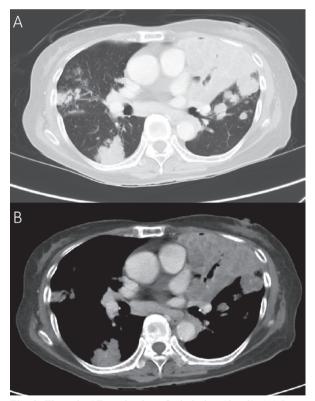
Thoracic CT on the day of admission (day 0). (A) Lung window of thoracic CT showed multifocal, conglomerated soft tissue at the bilateral lungs, with upper lobes and left upper lobe lingual segment predominance, and a peripheral, wedge-shaped, acinar distribution. (B) Mediastinal window of thoracic CT showed multiple mass-like lesions at the bilateral lung fields. Some low-attenuating components and air bronchogram were also noted.
